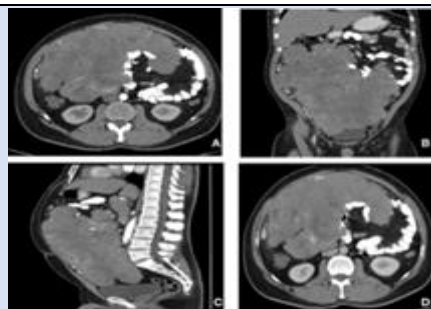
(A, B, C and D) - arterial phase axial (8A), coronal (8B), Sagittal (8C) and venous phase axial (8C) section images of CT Abdomen with contrast show mild heterogenous enhancement of the lesion with few non enhancing central necrotic areas. Possibility of omental, mesenteric GIST and desmoid tumor were given as diagnosis.
